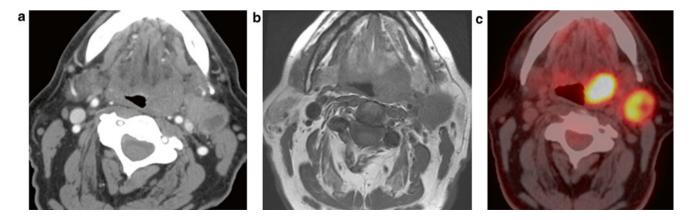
Imaging evaluation of a T2 N2b M0 left base of tongue squamous cell carcinoma by various modalities: (a) CT with iodinated contrast (b) MRI (c) PET/CT
